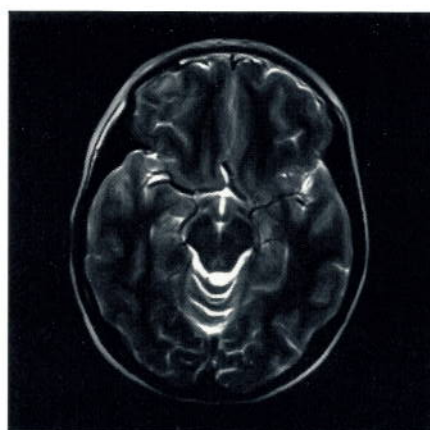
Turbo Spin Echo T2-weighted pediatric head, sequence used was TSE5_16b130_98b130.wkc, TR 3000 ms, TE 16/98 ms, Flip 180 deg, FOV 210 mm, 6/8 RecFOV, Swap, matrix 190 x 256o, slice 5 mm, 2 acquisitions, scan time 4- min, F:9 image filter. (Courtesy of Childrens Hospital of Philadelphia)
